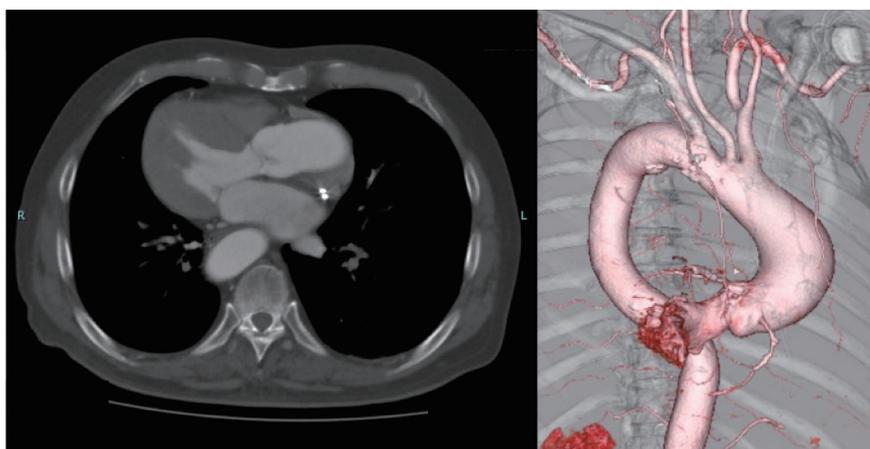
Contrasted-enhanced CT with 3D reconstruction.
